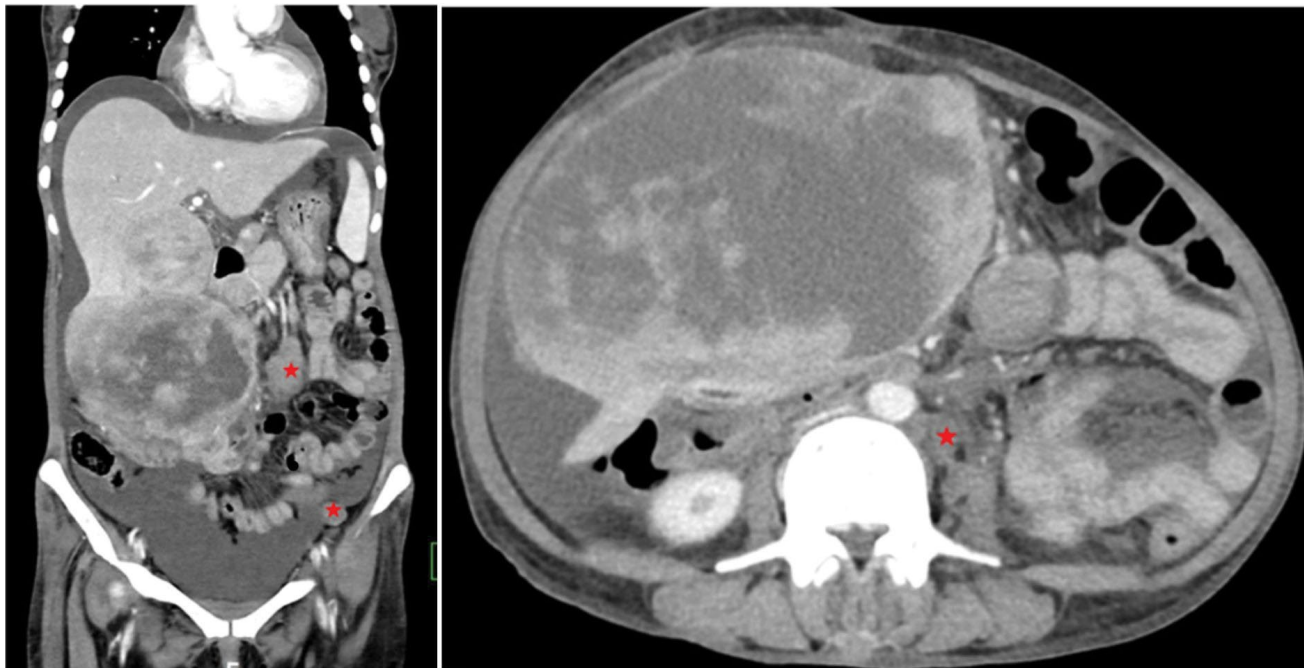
Hepatic lymphoma. (a,b) Contrast enhanced CT coronal and axial sections shows an irregular heterogeneously enhancing exophytic mass lesion arising from right lobe of liver with central non-enhancing hypodense areas (necrosis). Multiple heterogeneously enhancing mesenteric, para aortic and left external iliac lymph nodes seen (★ red star). Moderate ascites present.
